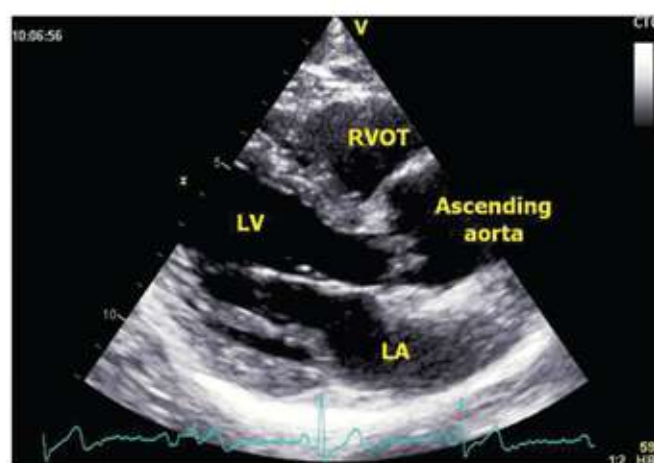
Parasternal long-axis view. LA- left atrium, LV- left ventricle, RVOT- right ventricular outflow tract
